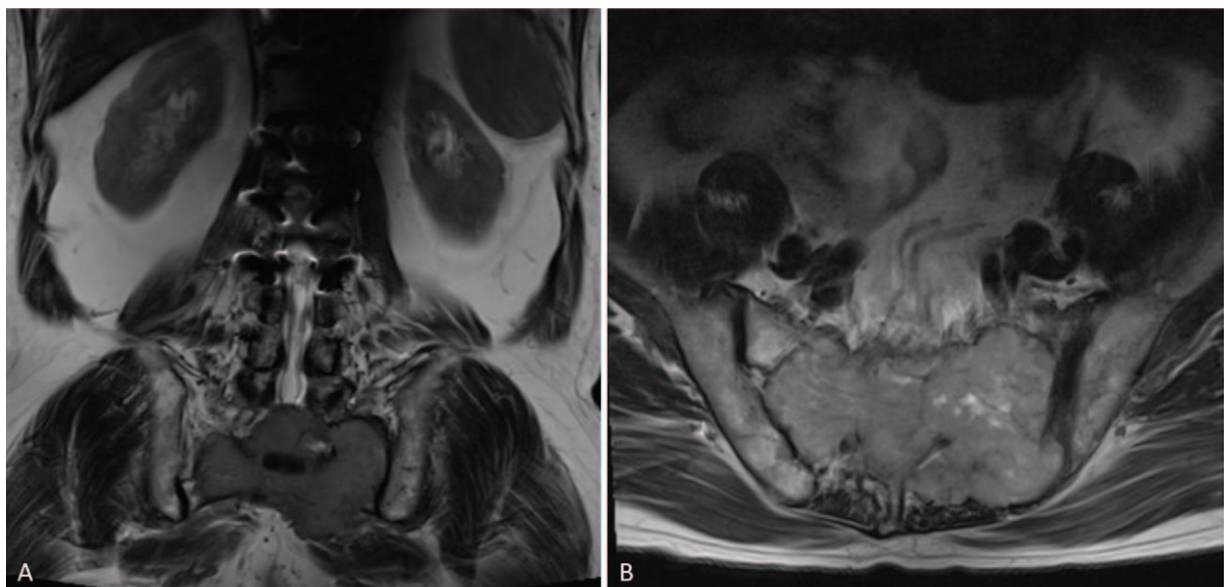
(A,B) Preoperative coronal and transverse MRI images showing sacral metastases of B3 thymoma. MRI = magnetic resonance imaging.
